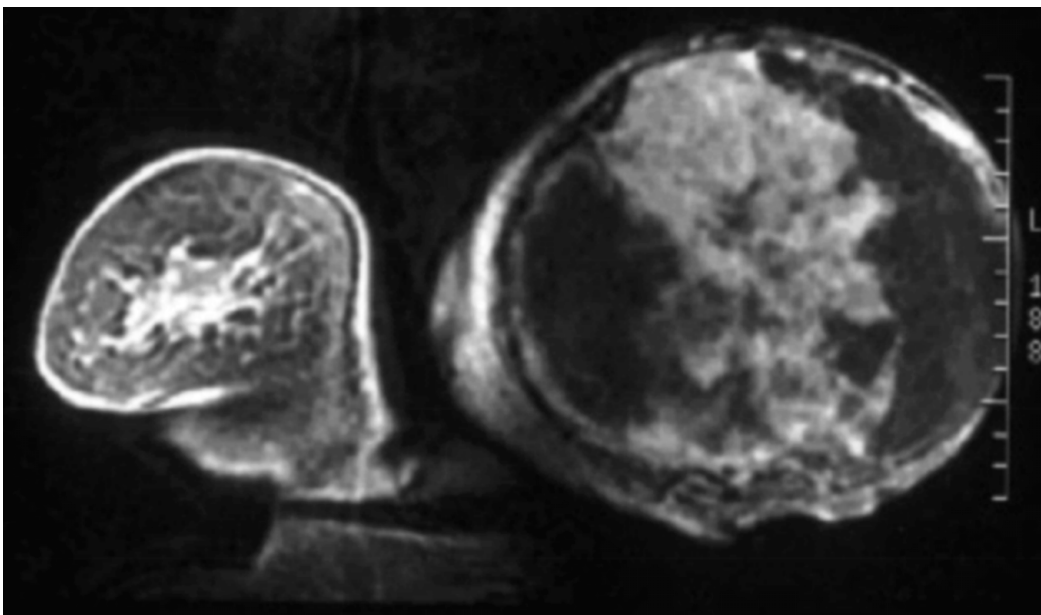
MRI (coronal fat suppression sequence). Voluminous neoformation in the left breast with inhomogeneous enhancement.
